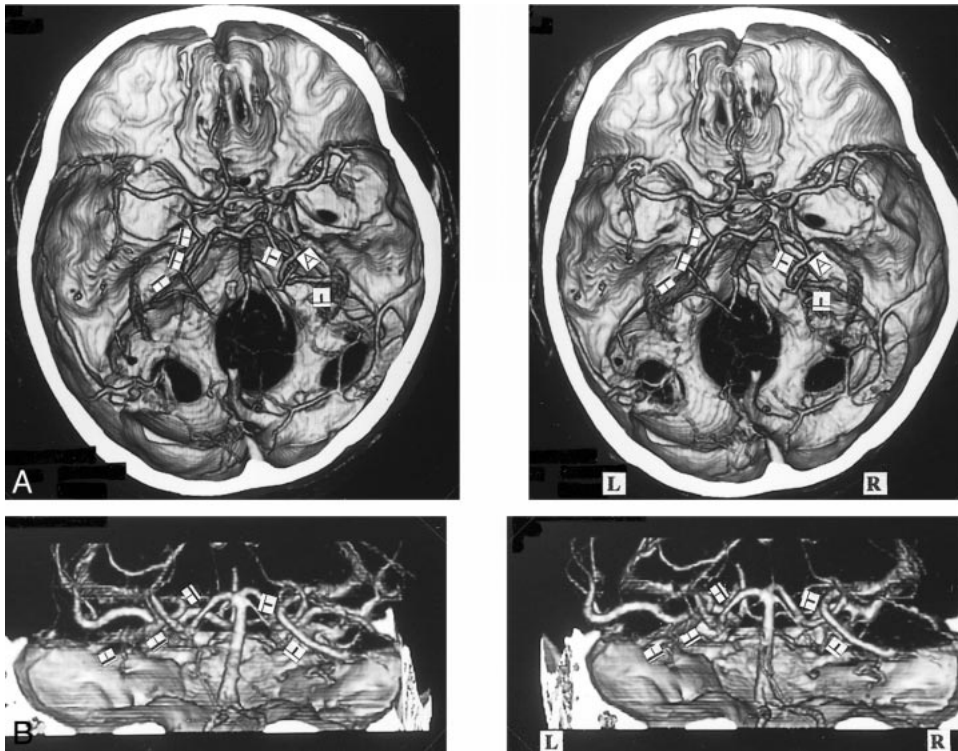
A, 3D CT angiogram (axial, stereoscopic views) and B, posteroanterior stereoscopic views. The bilateral BVRs drain via the lateral mesencephalic vein (\blacktriangle , \blacktriangleleft) into the superior petrosal sinus. In the presence of a hypoplastic third segment of the BVR, the right inferior ventricular vein (∇) enters the lateral mesencephalic vein. The left third segment enters the great vein of Galen.
